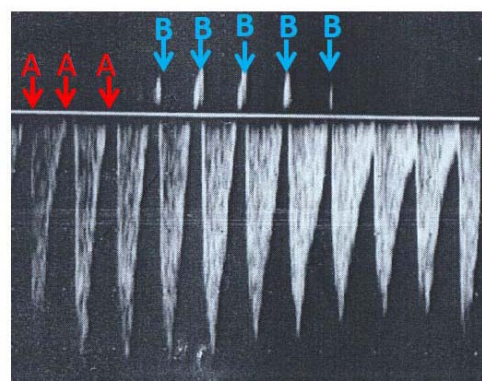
Umbilical artery Doppler wave form in the smaller twin at 21 weeks. Intermittent absent (arrows A) and reversed (arrows B) end-diastolic flow (iAREDF) is noted.
